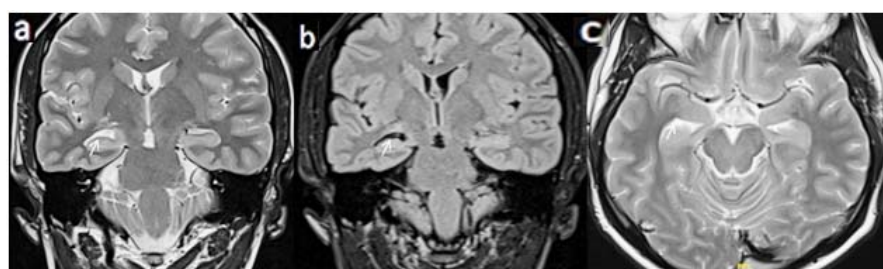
(a) T2 coronal, (b) FLAIR oblique Coronal, (c) T2 axial showing loss of striations on the right side with loss of volume in right hippocampus
